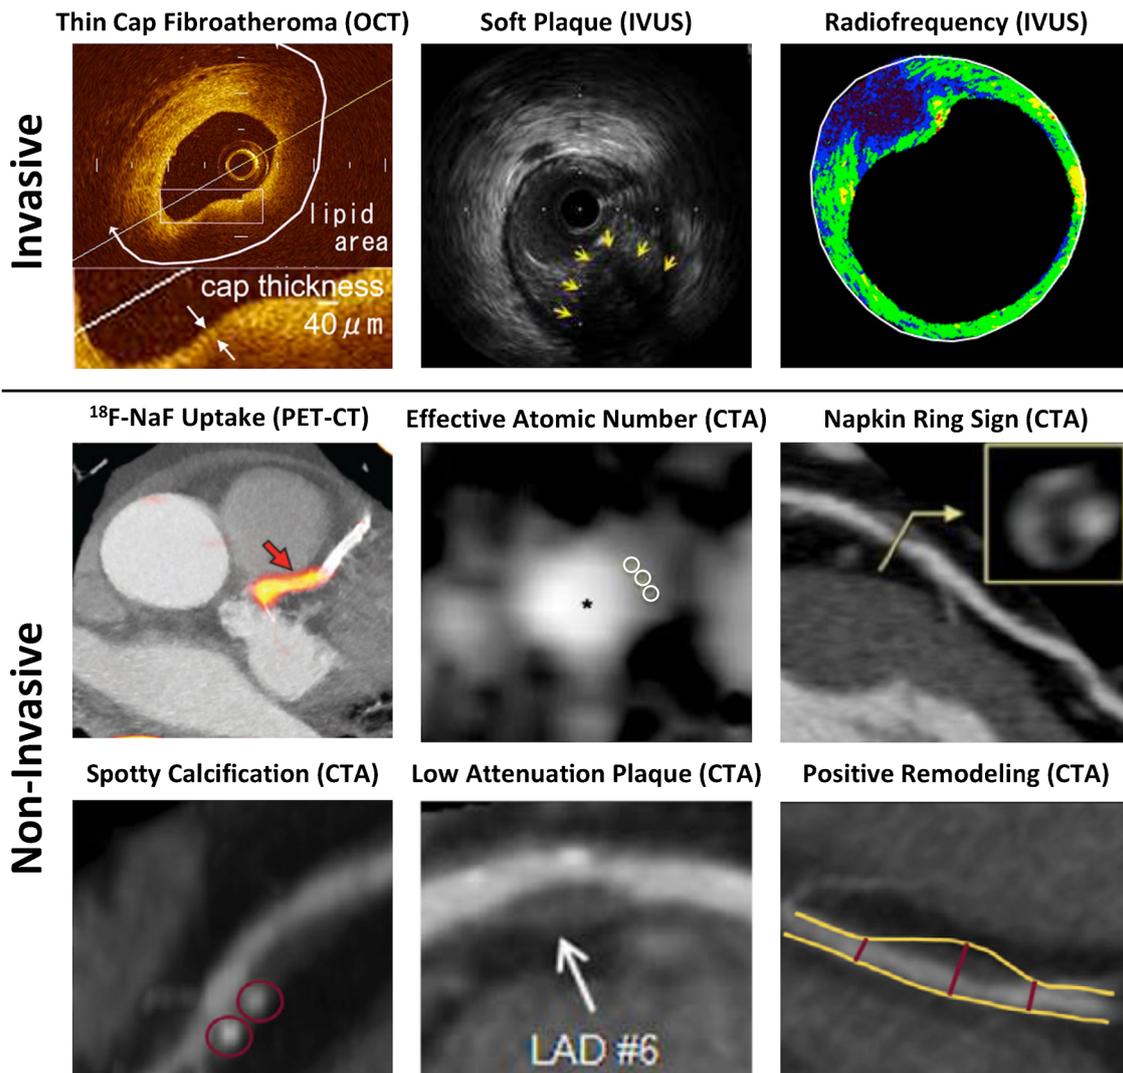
Examples of plaque measures identified by invasive and noninvasive imaging: a optical coherence tomography (OCT) demonstrating thin-cap fibroatheroma; b intravascular ultrasound (IVUS) identified soft plaque (yellow arrows); c color-coded integrated backscatter IVUS images of coronary artery plaque and overlying fibrous cap (fibrous [green], dense fibrosis [yellow], lipid pool [blue and purple], calcification [red]); d positron emission tomography computed tomogram
